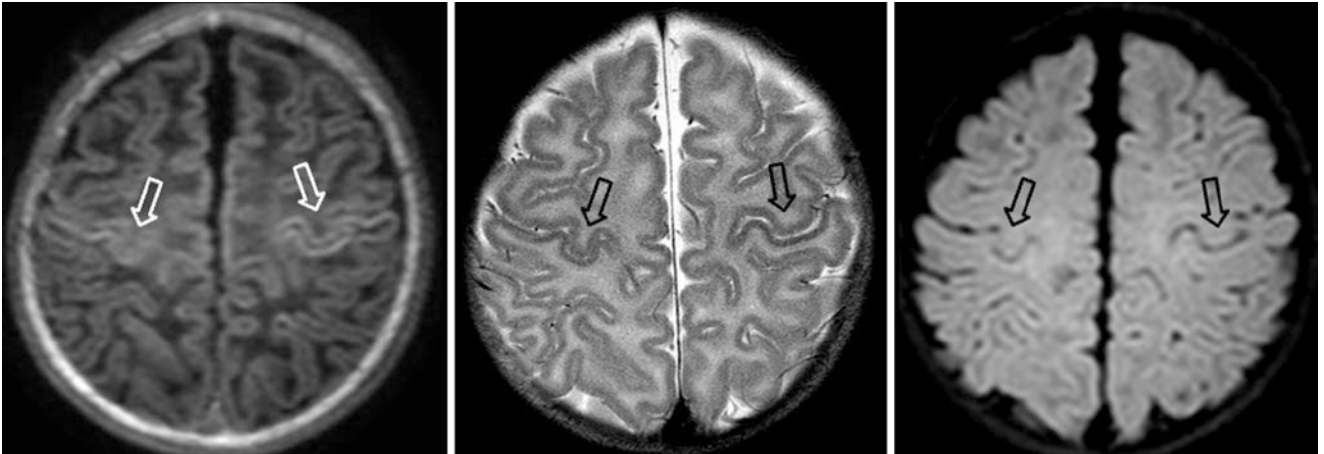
A 17-day-old term neonate had a normal 3T MRI with GE T1WI (*left*), SE T2WI (*left middle*), and axial reformat from a 3D FLAIR acquisition (*right*). The PRC (*open arrows*) is visualized as
